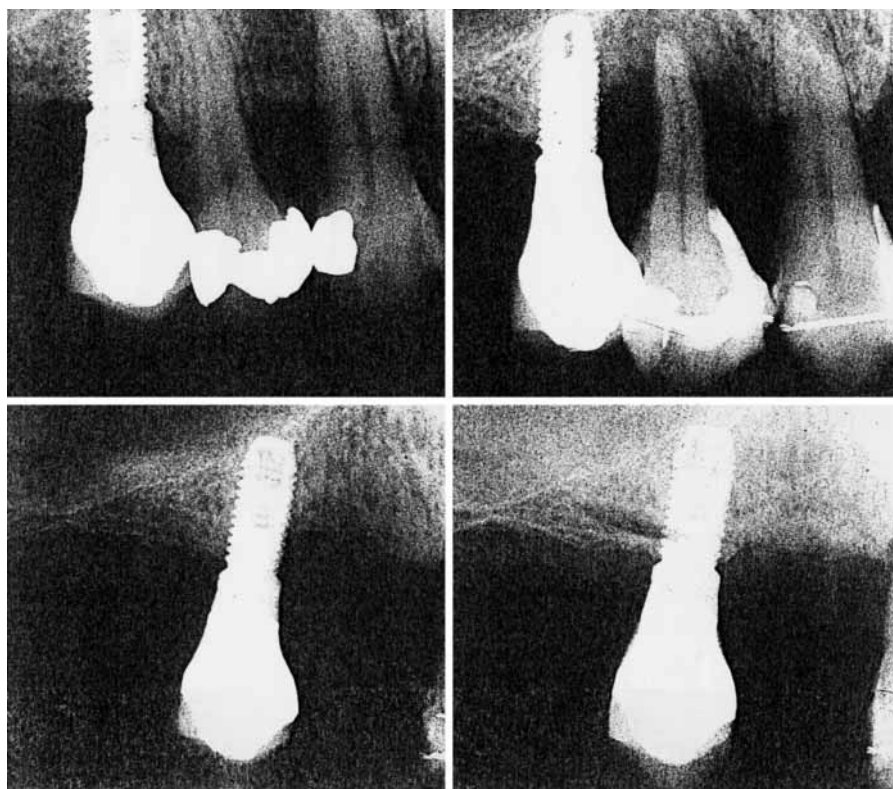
An example of the resistance to peri-implantitis of screw-shaped implants with a machined surface (Brånemark system). Radiographs of a patient (partially edentulous upper jaw rehabilitated with Brånemark implant) suffering from rapidly progressing periodontitis but without signs of peri-implantitis. Upper left: radiograph from both implant (position 15) and neighbouring teeth in 1989, this is some years after
